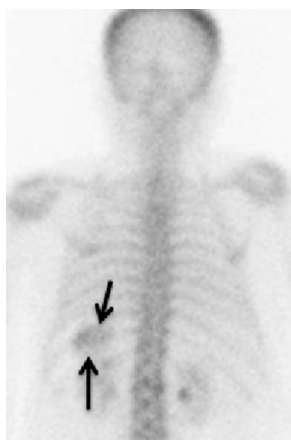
Posterior view in bone scintigraphy showing extra-osseous radiotracer uptake in the left upper abdomen (arrows)
